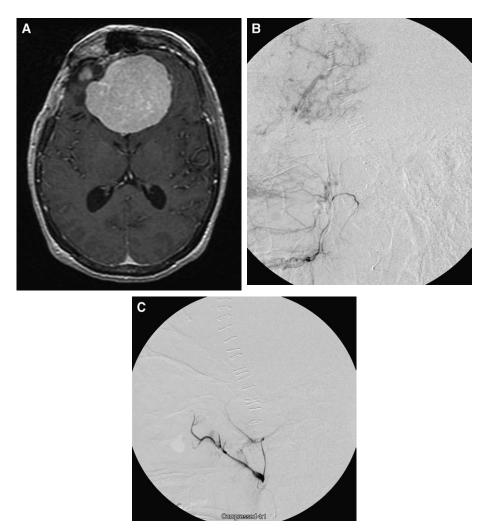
(A) Axial postcontrast T1-weighted MRI shows a giant anterior skull base hemangiopericytoma. (B) Superselective injection of the internal maxillary artery shows a prominent tumor blush. (C) No tumor blush is seen after embolization with particulates (polyvinyl alcohol).
